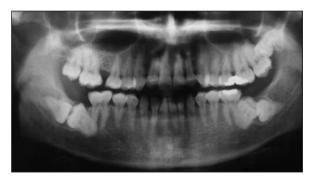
(Case 4) Panoramic radiograph showing KM in the right mandible.
